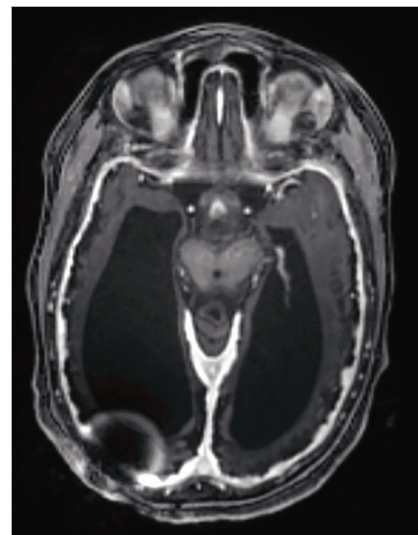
Brain magnetic resonance imaging scan of a 5-year-old child with cortical/cerebral visual impairment and multiple contributing etiologies, including hydrocephalus with a ventriculo-peritoneal shunt (artifact seen on the scan), hypoxic-ischemic encephalopathy with extensive cerebral volume loss, and seizures.
